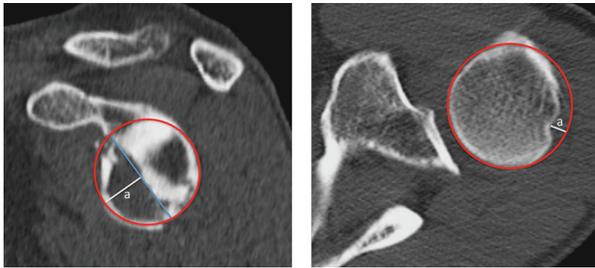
Computed tomography (CT) scan of a left shoulder. (Left) Sagittal plane showing severe glenoid bone loss. The amount of bone loss is calculated as the ratio a/d of the width of the defect (a) to the diameter (d) of the assumed outer fitting circle. (Right) Axial plane showing a Hill-Sachs lesion loco typico. The maximum depth of the Hill-Sachs lesion is calculated as the ratio a/d of the depth of the defect (a) to the diameter (d) of the assumed outer fitting circle.
